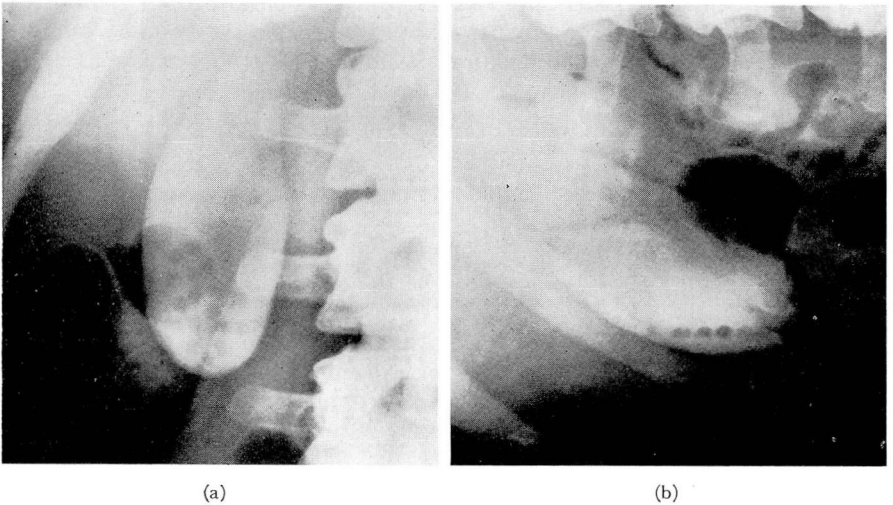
Cholelithiasis. (a) Posteroanterior prone roentgenogram showing several obvious nonopaque calculi. (b) Posteroanterior lateral decubitus roentgenogram where "layering" of calculi is demonstrated.
